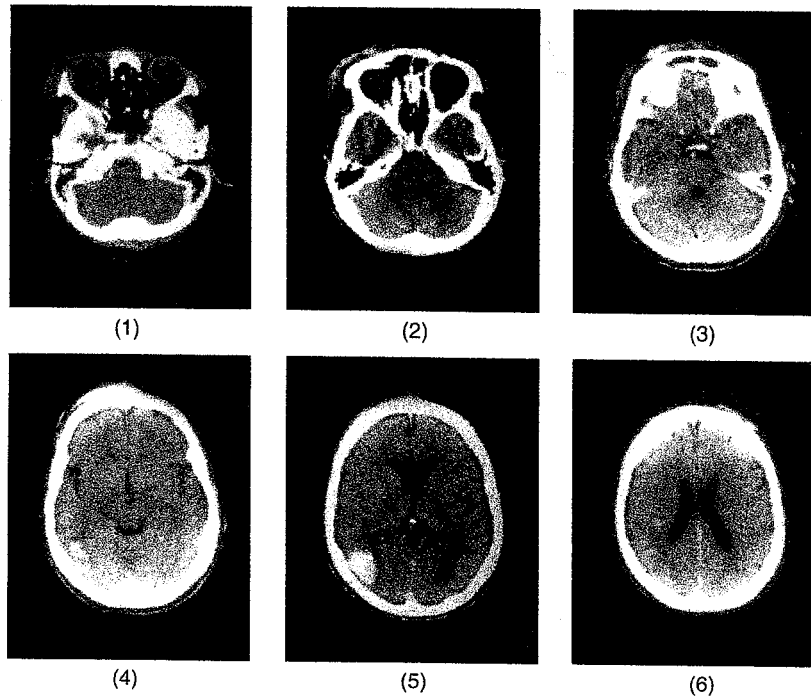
CT Scans of a Lesion. The patient had a lesion in the right occipital-parietal area (scan 5). The lesion appears white because it was accompanied by bleeding; blood absorbs more radiation than does the surrounding brain tissue. Rostral is up, caudal is down; left and right are reversed. Scan 1 shows a section through the eyes and the base of the brain.
